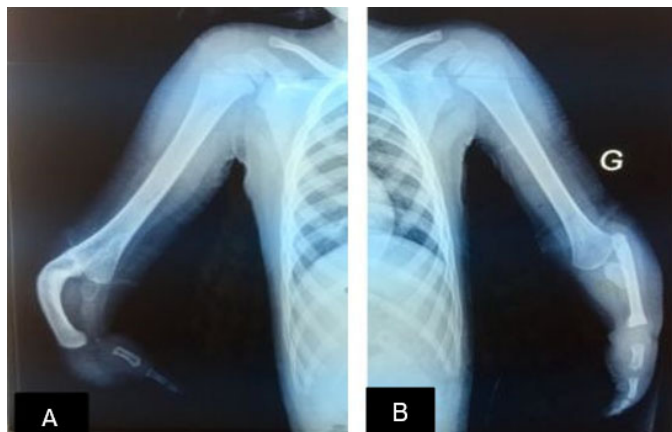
Upper limbs X-ray exam showing bilateral abnormalities, with partial ulnar aplasia with absent carpal bones and all digits other than the index fingers on the right side in A, also exhibiting radio humeral synostosis and radial inclination.
